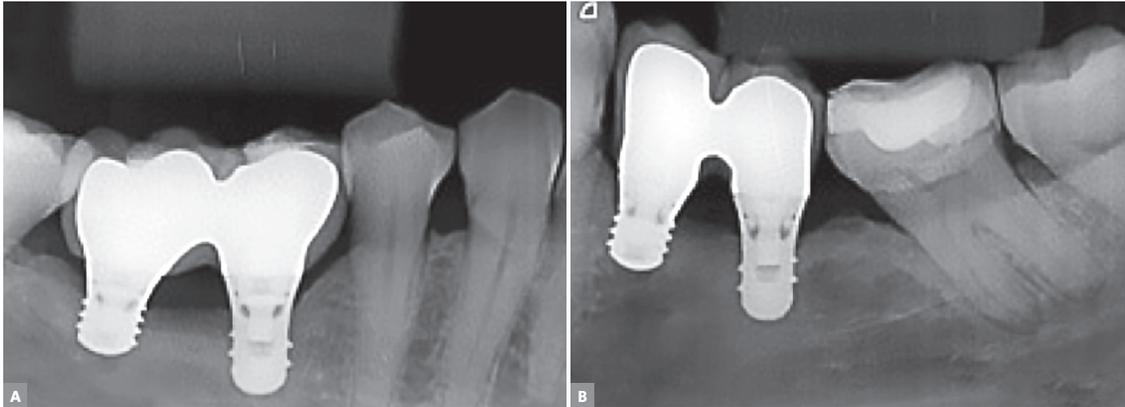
Control periapical radiograph one year after treatment completion. Note extrashort implants recommended due to decreased bone height associated with inferior alveolar nerve, mental foramen and proper prosthetic fitting, in addition to crown-implant ratio.
